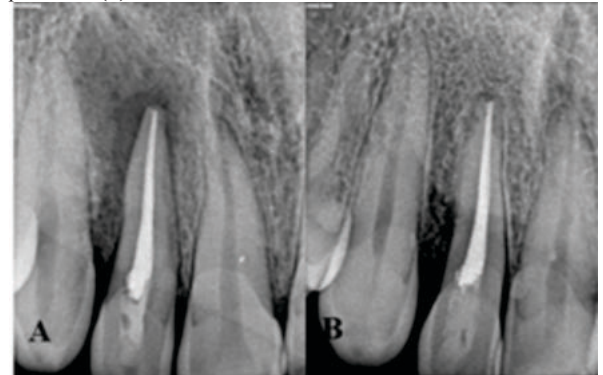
Immediate Postoperative radiograph(A) and follow-up radiograph after two years showing healing of periapical lesion(B)
